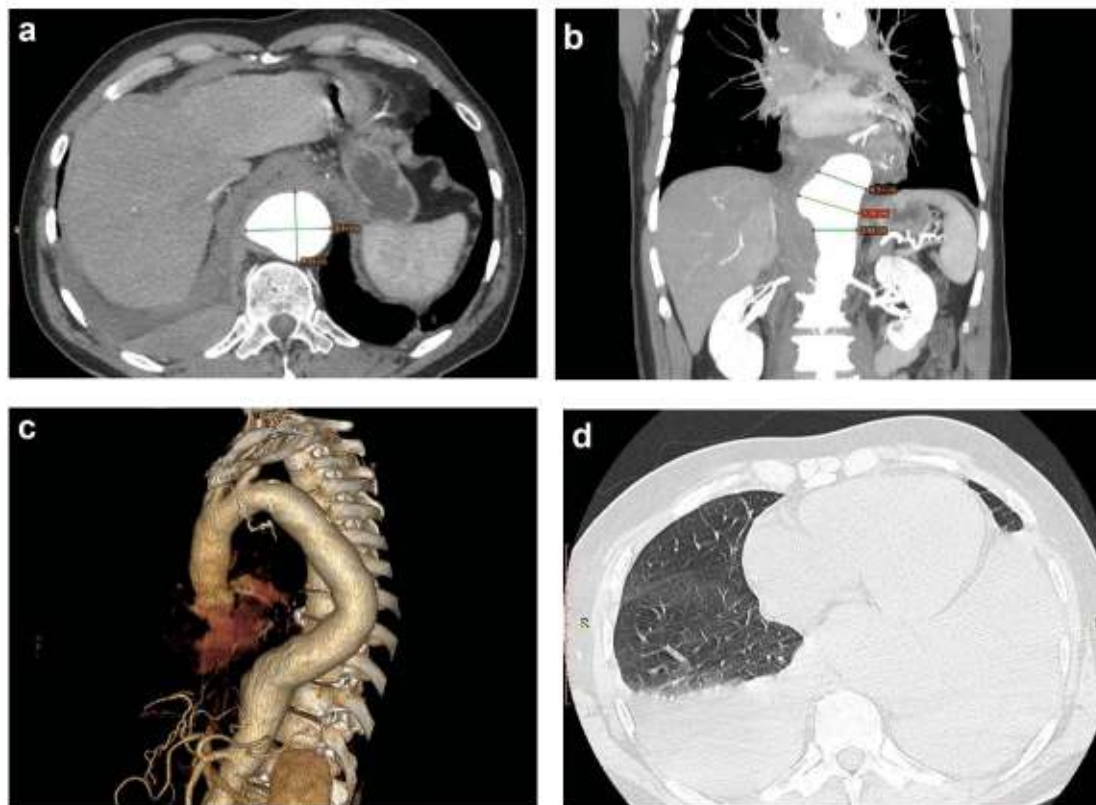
(A) Axial, (B) Coronal contrast-enhanced CT at the onset of the disease; (C) 3D CT reconstruction; (D) Deferred axial CT scan after two weeks from disease onset.
